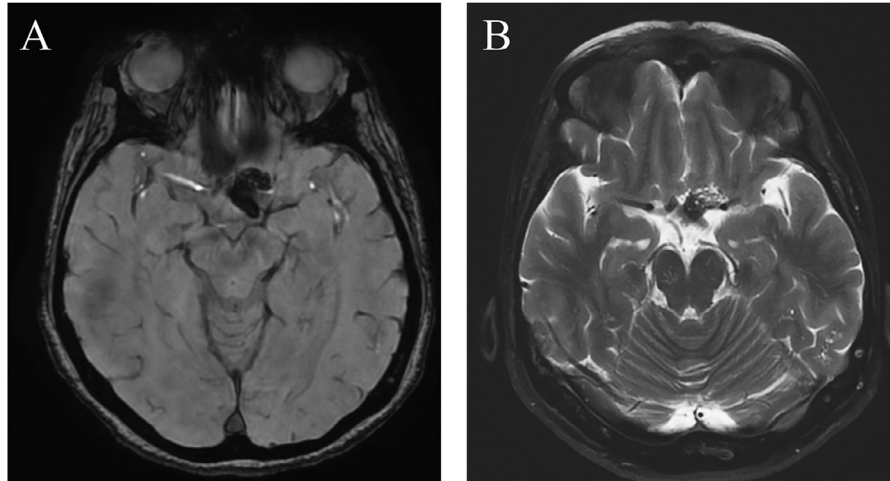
A) Axial T1-weighted gadolinium-enhanced MRI, and B) axial T2-weighted MRI showing a left side non-enhancing hypointense suprasellar lesion, in a 62-year-old woman.
